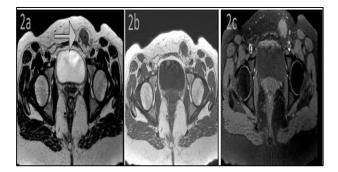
(A-C): T2-weighted axial image revealed an irregular lesion (arrow) with intermediate signal intensity, extending through the left inguinal canal into the left pubic area. The mass was mainly hypointense on T1-weighted image and appeared hyperintense on fat-suppressed T1- weighted image suggestive of hemorrhage.
